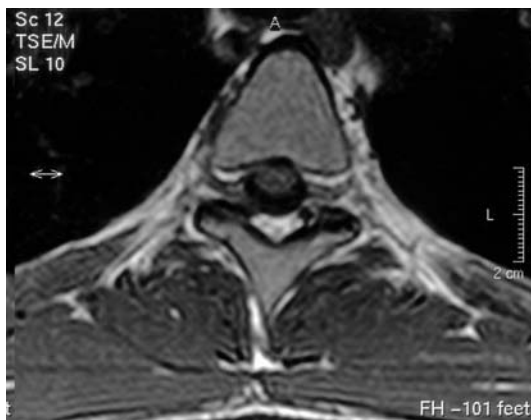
Axial T1-weighted image of the thoracic spine at the level of the T8-9 neural foramina. In relation to the transverse diameter, the anteroposterior diameter of the thoracic vertebral bodies is greater than that of the cervical vertebrae. The nerve roots emerge at an angle of approximately 90°. Within the foramina, the nerve roots are identified by their low signal relative to the bright fatty tissue. The extensor and other back muscles are seen as low-signal-intensity structures relative to fatty tissue in the individual muscle compartments and fasciae. The black areas to the right and left of the vertebral body are the air-filled lungs, which emit no signal. A T8 vertebral body, B dural sac, C left T8 nerve root, D vertebral arch/spinous process, E lung
